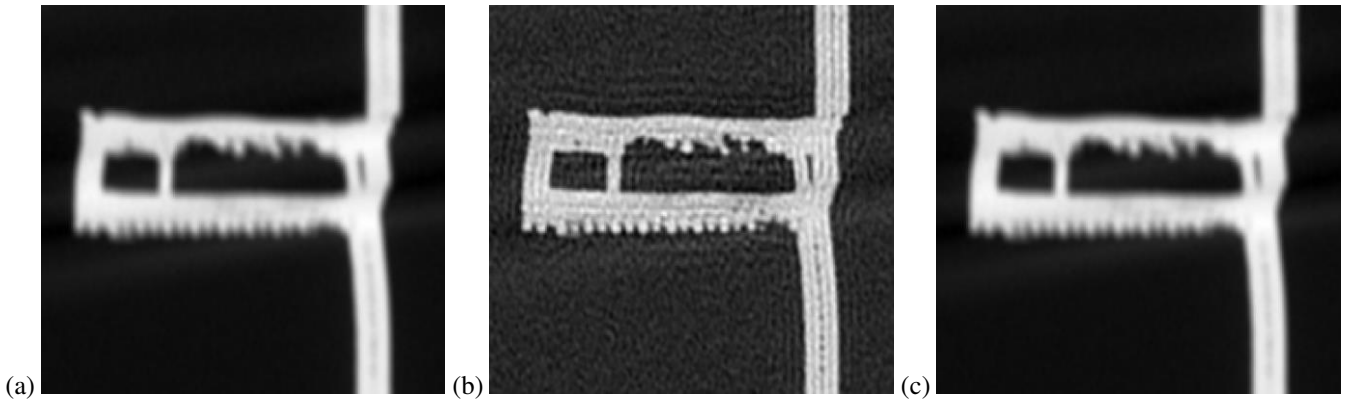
AM lattice cylinder X slice of CT reconstruction (a) baseline no deconvolution, (b) Wiener filter, and (c) conjugate gradient deconvolution.
